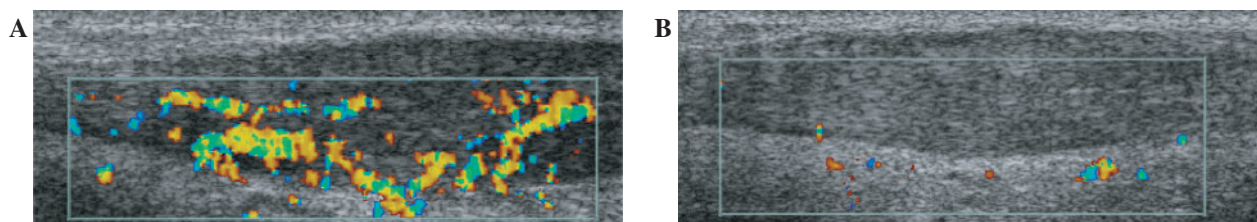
Beneficial effect of eccentric training on neovascularization of the Achilles tendon. (A) Achilles tendon prior to eccentric loading programme. Significant neovascularization on power Doppler study. (B) Achilles tendon after eccentric loading programme. Absent neovascularization on power Doppler study. Image reproduced from Öhberg L, Alfredson H. Effects of neovascularisation behind the good results with eccentric training in chronic mid-portion Achilles tendinosis. *Knee Surg Sports Traumatol Arthrosc* 2004;12:465–70, with kind permission of Springer Science and Business Media.) This figure may be viewed in colour as supplementary data at *Rheumatology* Online.
